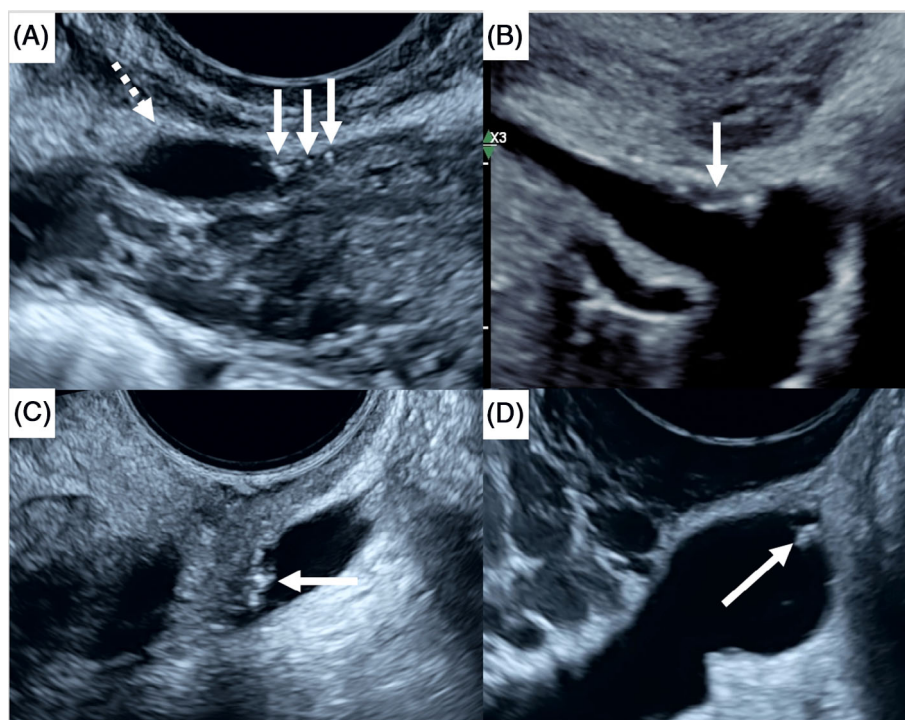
Examples for superficial endometriosis as they appear sonographically. (A) A cystic lesion on the anterior/right surface of the uterus (dashed arrow) with a subtle adjacent area of isoechoic tissue contain echogenic foci (solid arrows). Echogenic foci are a typical feature of superficial endometriosis on ultrasound. (B) A hypoechoic lesion arising from the surface of the peritoneum in the pouch of Douglas, again with associated echogenic foci. (C and D) Echogenic projections seen from the peritoneum in the pouch of Douglas protruding into the physiological free fluid (D).
